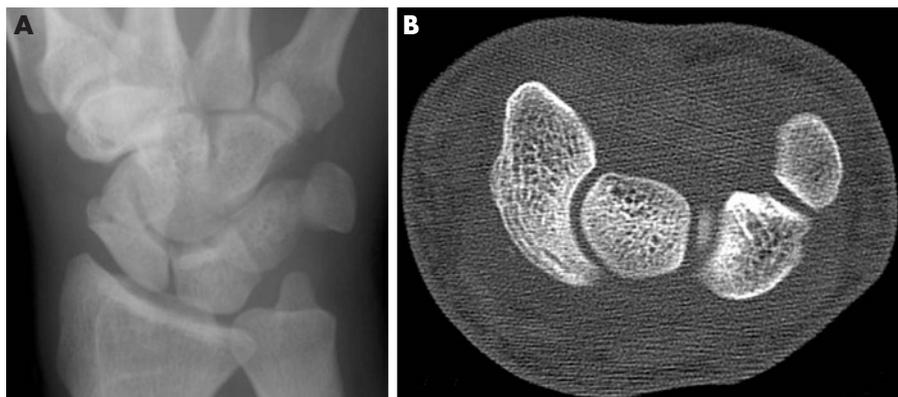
A 35-year-old man with a motor vehicle injury. (A) Posteroanterior radiograph of the wrist shows definite fracture line in the scaphoid. (B) Axial CT image showing normal scaphoid.
